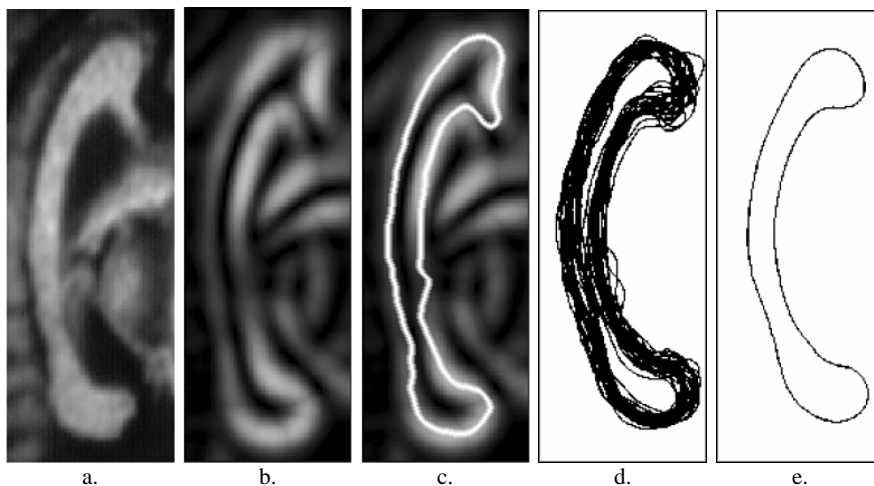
A progressive view of modeling the corpus callosum across multiple subjects. 5a: mid-sagittal MR image of a human brain cropped to show the corpus callosum; 5b: *Low-level image processing* – cropped image from (5a) after a simple gradient magnitude edge detector has been applied; 5c: *Segmentation*: shape segmented using the edge strength image in (5b); 5d: *Registration*: outlines of the same structure registered across 30 subjects showing the normal (expected) variation in shape within a sample population; 5e: the average or mean shape of a corpus callosum. (Adapted with permission from Szekeley, et al. (Szekeley, 1996)).
